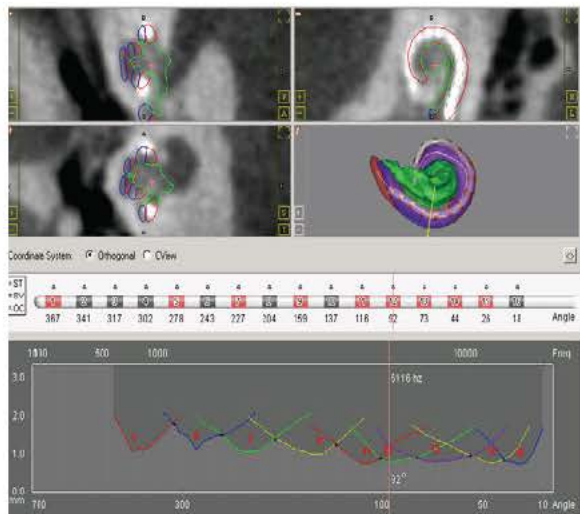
Software module defining electrode to neural interface in CT scans and 3D reconstruction (top panel: red=ST, blue=SV, and green=modiolus). Middle panel shows active electrodes in red. Bottom panel shows distance vs frequency curves used to deactivate electrodes interfering with neighboring electrodes.
